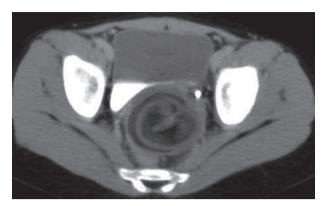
Axial view on multidetector computed tomography (MDCT) of the abdomen shows an ovoid-shaped mass with fat and soft-tissue components below the bladder.
